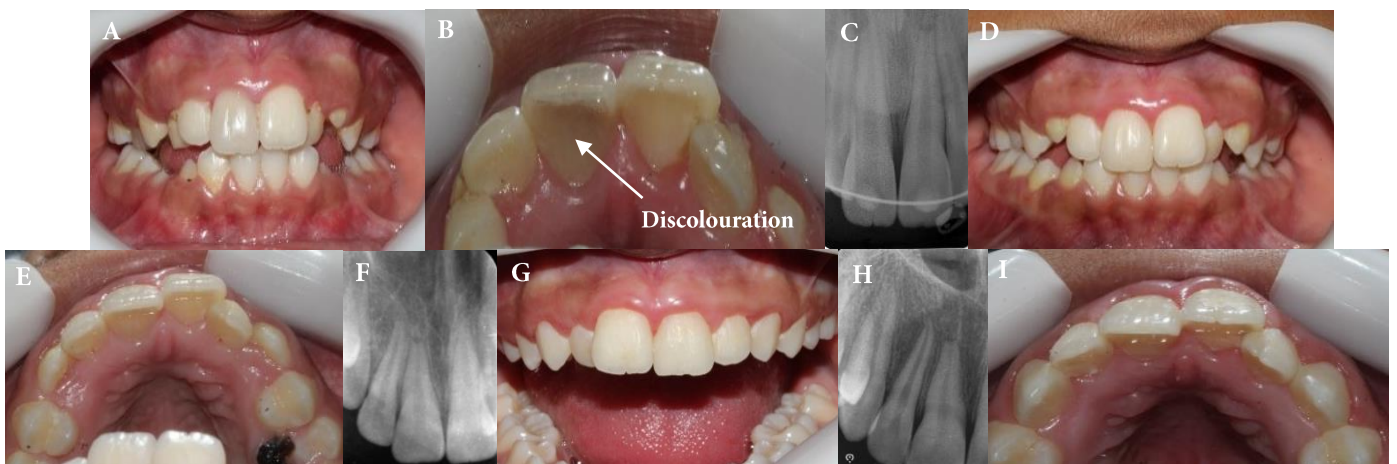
Follow-up photographs and periapical radiographs, A-C) 1-month follow-up; D-F) 4-month follow-up; G-I) 15-month follow-up
